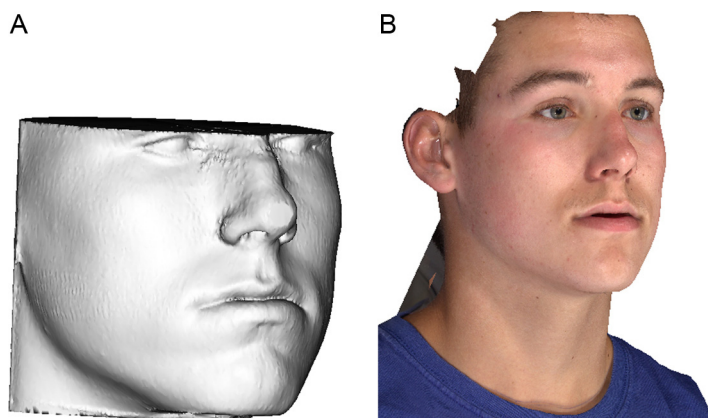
(A) Soft tissue prediction from the CBCT volume. (B) Soft tissue prediction with 3D photographic overlay onto the CBCT volume.
